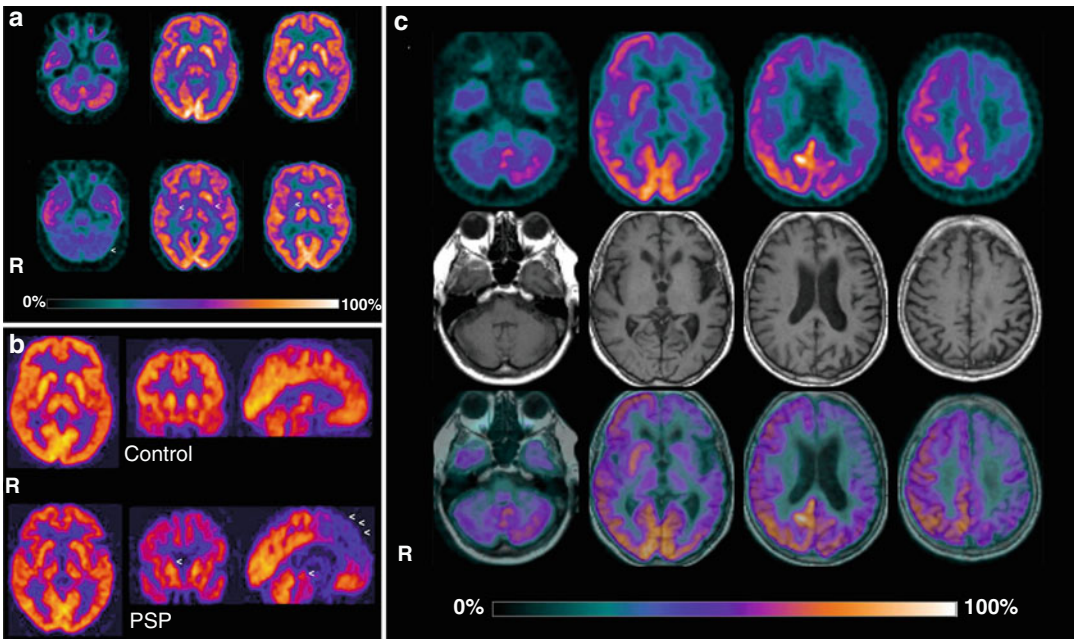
Left top panel (a)*, FDG-PET images in a control subject (*Top row*) and a MSA patient (*Bottom row*), showing decreased glucose metabolism in the putamen and cerebellar hemispheres (*arrowheads*). *Left bottom panel (b)*, FDG-PET images in a control subject and a PSP
